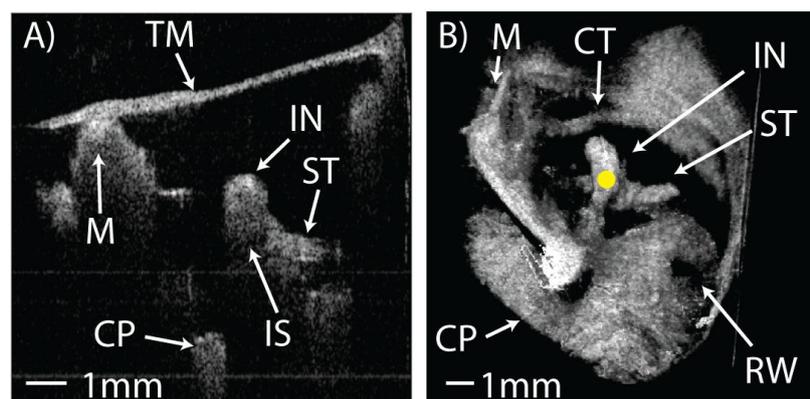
In vivo OCT imaging of a normal subject's left ear. A) Shows a $1 \times 1 \text{ cm}^2$ 2D cross-section of the middle ear in the transverse plane. B) Shows a $1 \times 1 \times 1 \text{ cm}^3$ 3D volume render of the middle ear as seen from the perspective of the ear canal with the TM digitally removed. Tympanic membrane (TM), malleus (M), incus (IN), incudo-stapedial joint (IS), stapedius tendon (ST), chorda tympani nerve (CT), cochlear promontory (CP), round-window niche (RW).⁷
